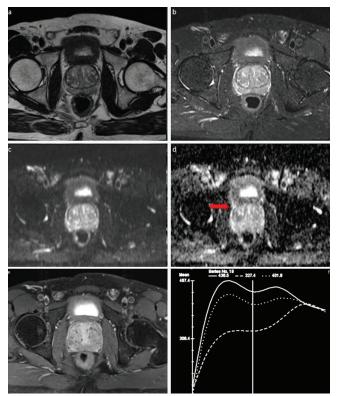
Axial T2 (a), Axial IR (b), DWI (c), ADC (d), Axial T1 post contrast (e) and DCE (f) images showing an ill-defined hypointense lesion in transition zone on right side showing early enhancement on dynamic contrast study. This is a PIRADS IV lesion.
